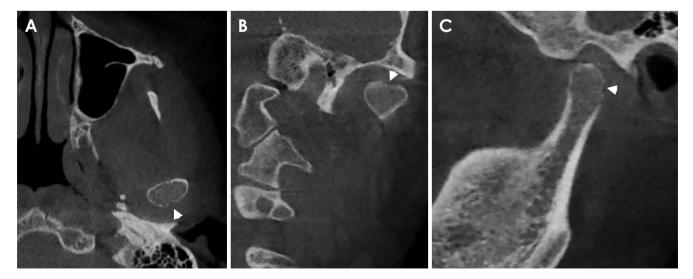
Axial (A), coronal (B), and sagittal (C) cone-beam computed tomographic images taken 1 month after the initial plain radiographs show a cortical discontinuity (arrow head) on the posterior surface of the left mandibular condyle.
